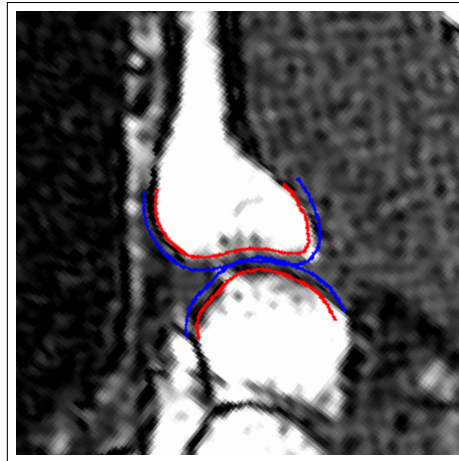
Bone and cartilage surfaces of the detail image, matched against the surface of the reference image, intersected and displayed in a slice of the reference MRI image
